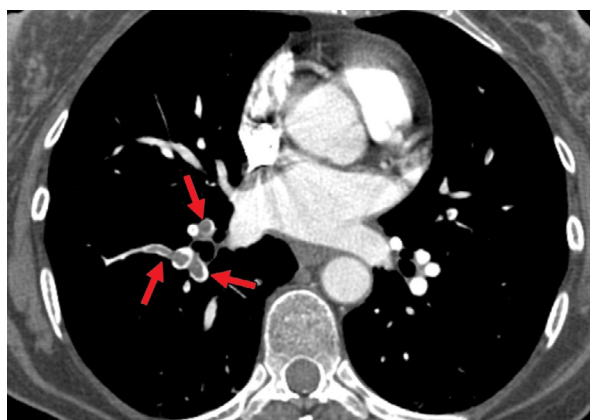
Computed Tomography pulmonary angiogram showing acute pulmonary embolism (red arrows) in right lower lobe pulmonary arteries
